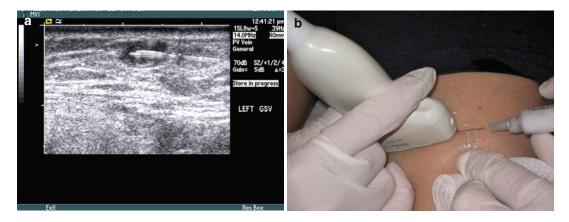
Advancing the needle along the long axis of the ultrasound probe. (a) ultrasound image of needle course into target vein and (b) visual image of injection technique
